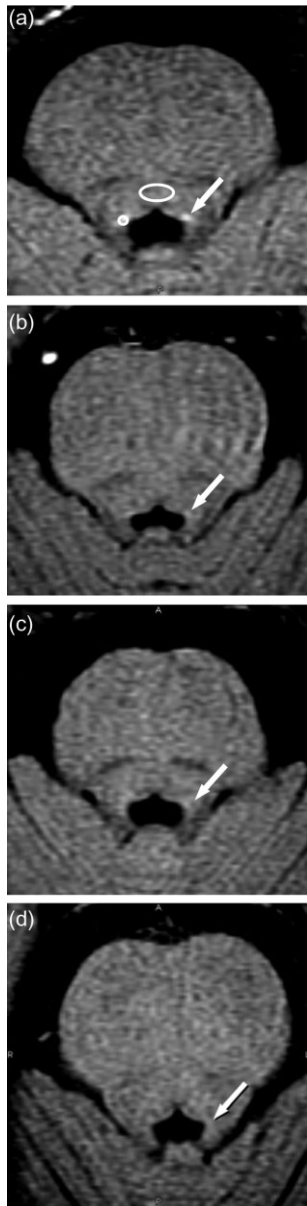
High-resolution fast spin-echo T1-weighted imaging of a healthy subject, patients with mild cognitive impairment (MCI) and a patient with Alzheimer's disease (AD). (a) A healthy subject. (b) A patient with MCI without conversion to AD (MCInc). (c) A patient with MCI converted to AD (MCIc). (d) A patient with AD. (a) In the healthy subject, a punctate region of high signal intensity showing the locus coeruleus (LC) is evident (arrow), (b–d) whereas the signal intensity is remarkably diminished in patients with MCInc, MCIc, or AD (arrows). Small circle, region of interest for measuring signal intensity in the LC (1 mm²); large circle, region of interest for the pontine tegmentum (10 mm²).
